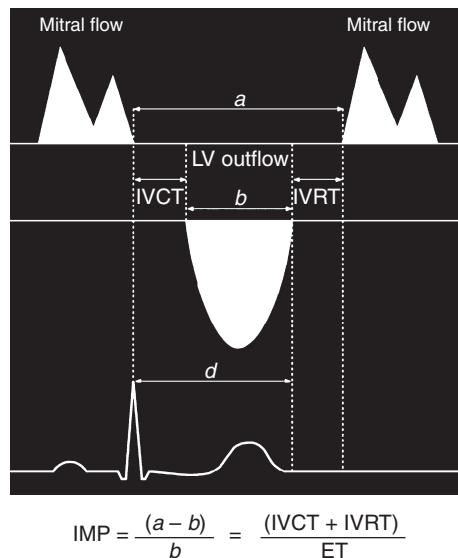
Flow Doppler at the mitral valve and at the left ventricular (LV) outflow tract. Measurements of time intervals used to calculate the index of myocardial performance (IMP). The interval *a* is measured from the end to the onset of the mitral inflow waveform; the interval *b* is the left ventricular outflow velocity tracing (ejection time). The IMP was calculated according to Tei et al.⁹ as $(a - b)/b$. IVCT, isovolumetric contraction time; IVRT, isovolumetric relaxation time.
